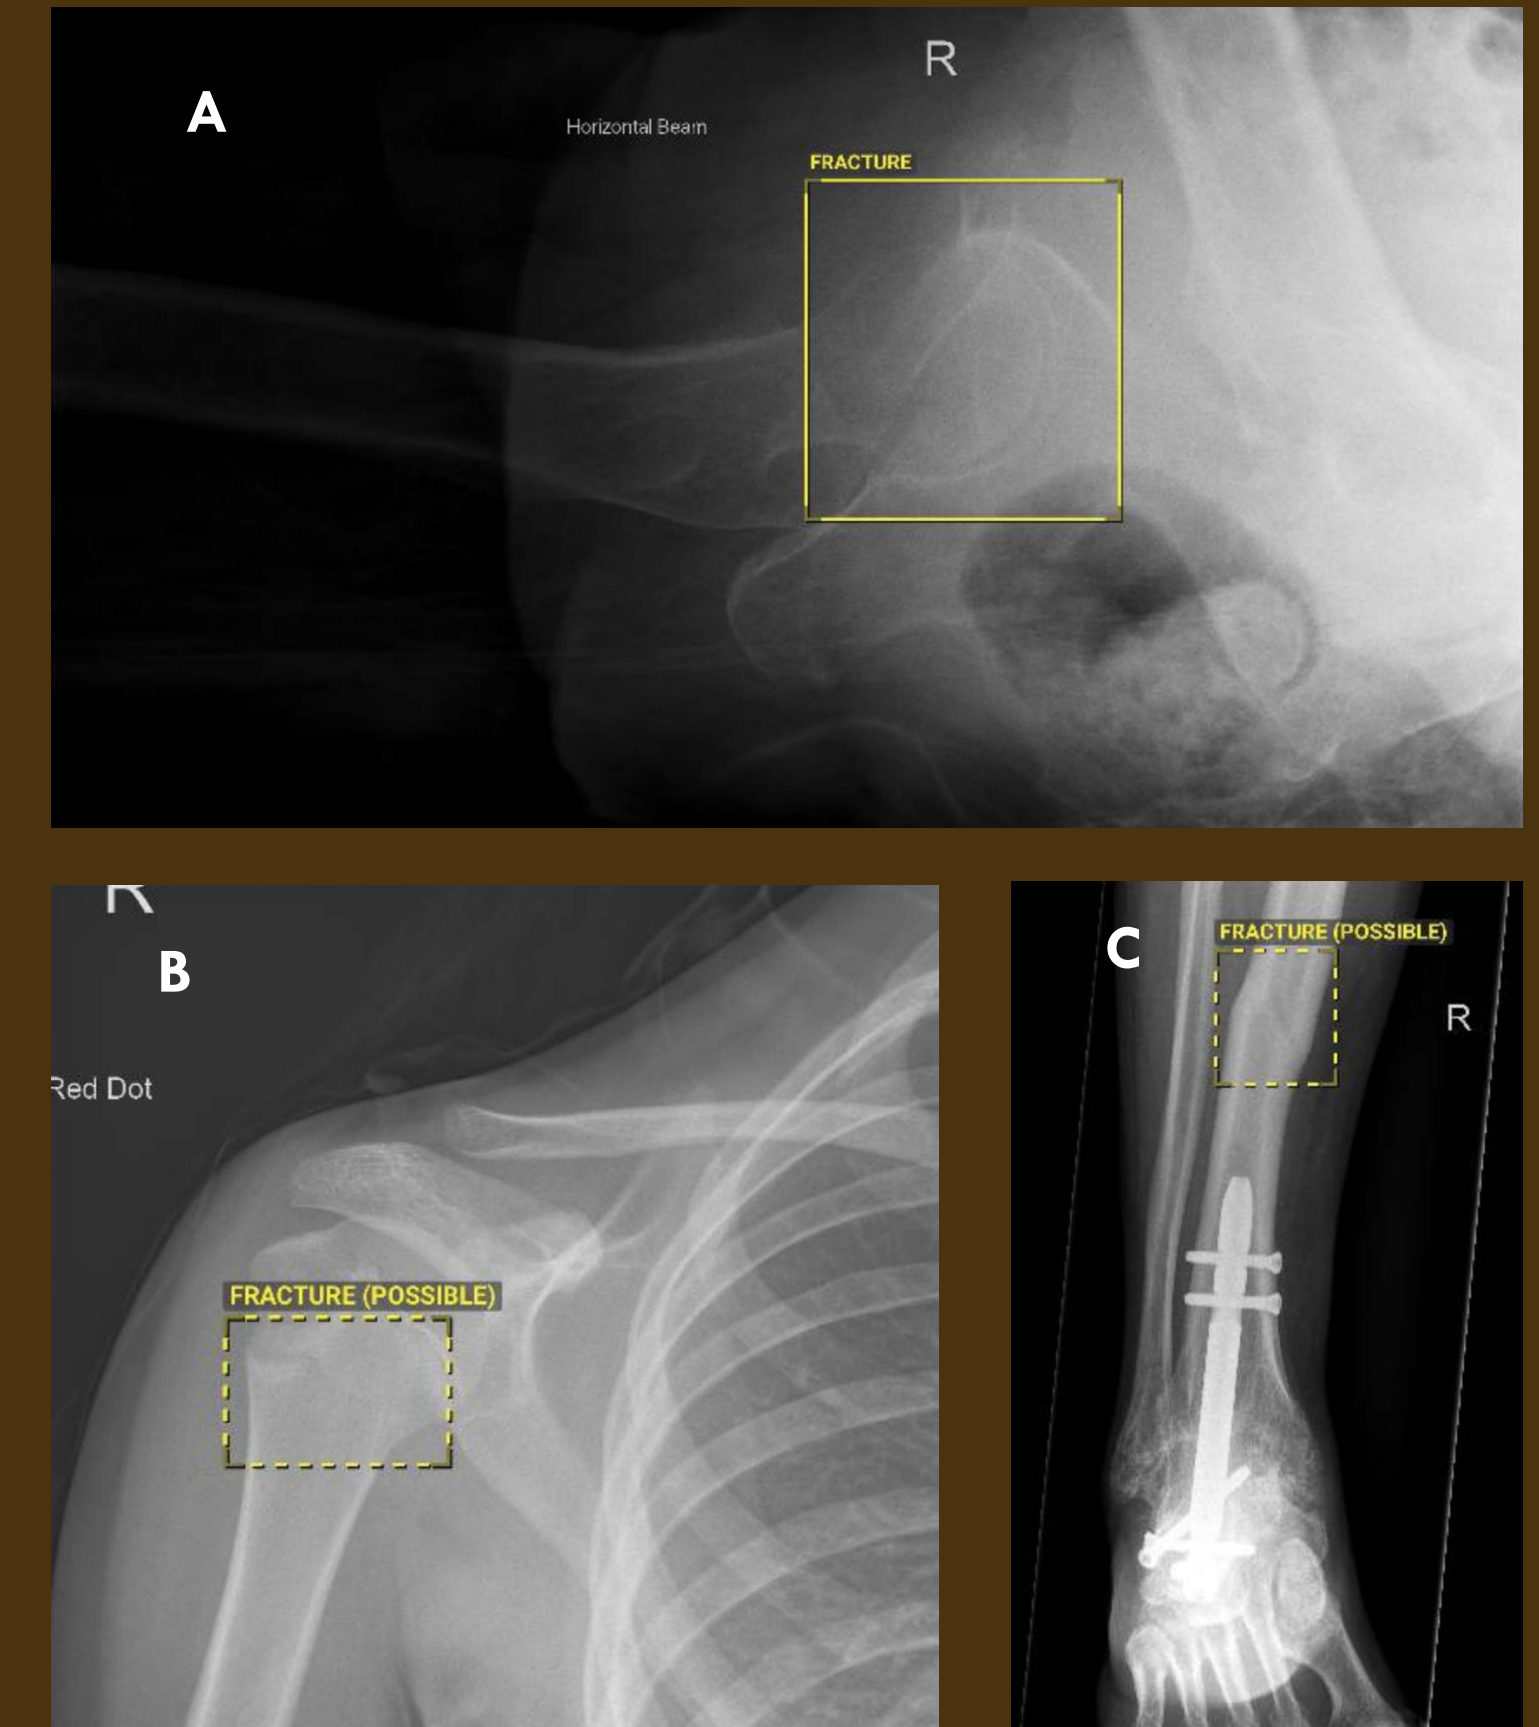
False positive cases. Case A was a significant error as this resulted in a CT hip that was not required. Other common false positives included growth plates (B) and old fractures (C).
